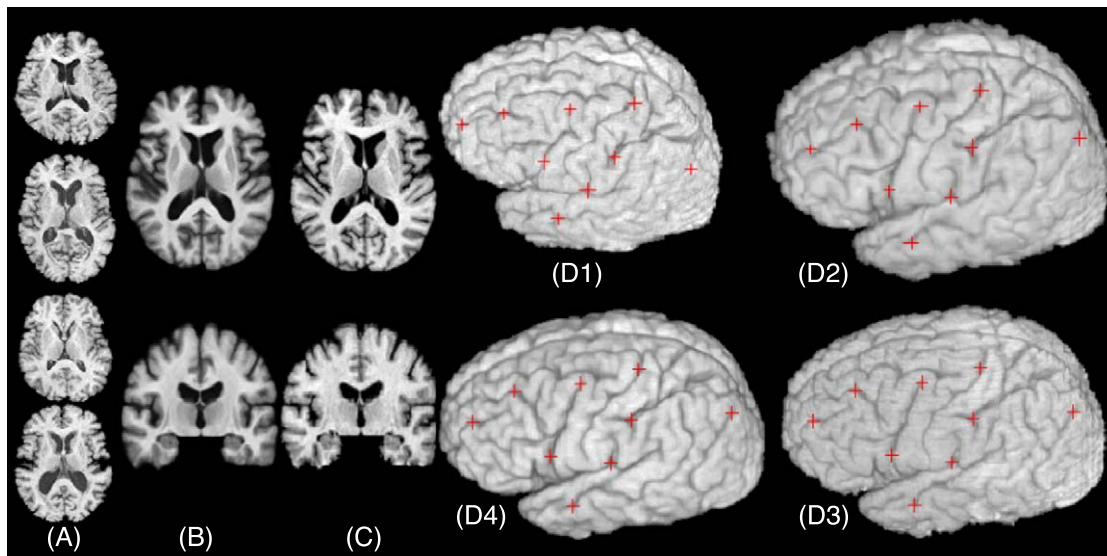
Results using the HAMMER warping algorithm. (A) Four representative sections from 18 MR images of the BLSA database. (B) Representative sections from the image formed by averaging the 18 images warped by HAMMER to match the template shown in C. (D1–D4) 3D renderings of a representative case, its warped configuration using HAMMER, the template and the average of 18 warped images, respectively. The anatomical detail seen in B and D4 is indicative of the registration accuracy. The red crosses in D1–D4 are identically placed to allow visualization of point correspondences.
